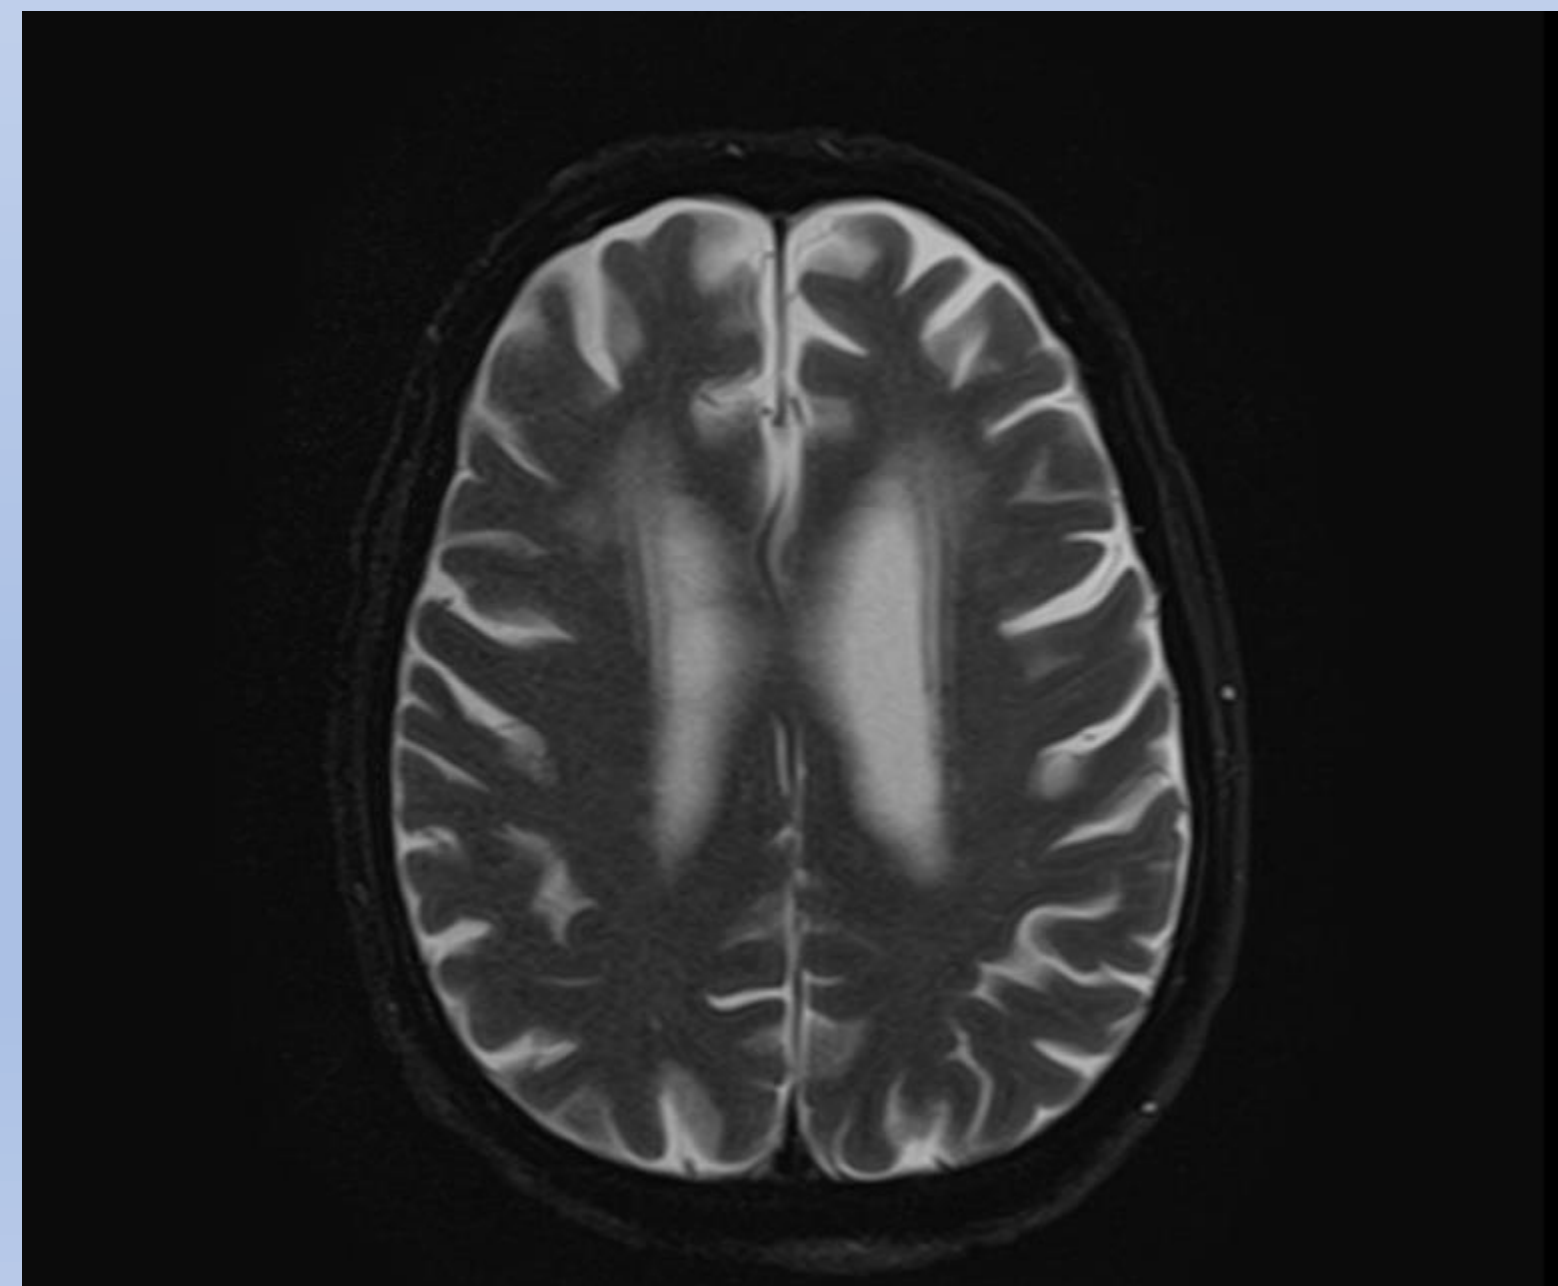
Multiplanar multisequence MRI of the brain without contrast was performed. 3 mm focus restricted diffusion along the right posterior corpus callosum suspicious for acute infarct.
